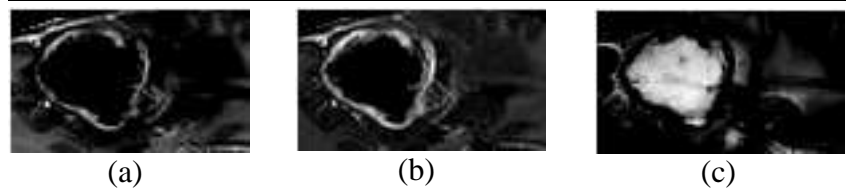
Intensity differences: (a) T1C-FLAIR, (b) T1C-T1, (c) T2-T1C
